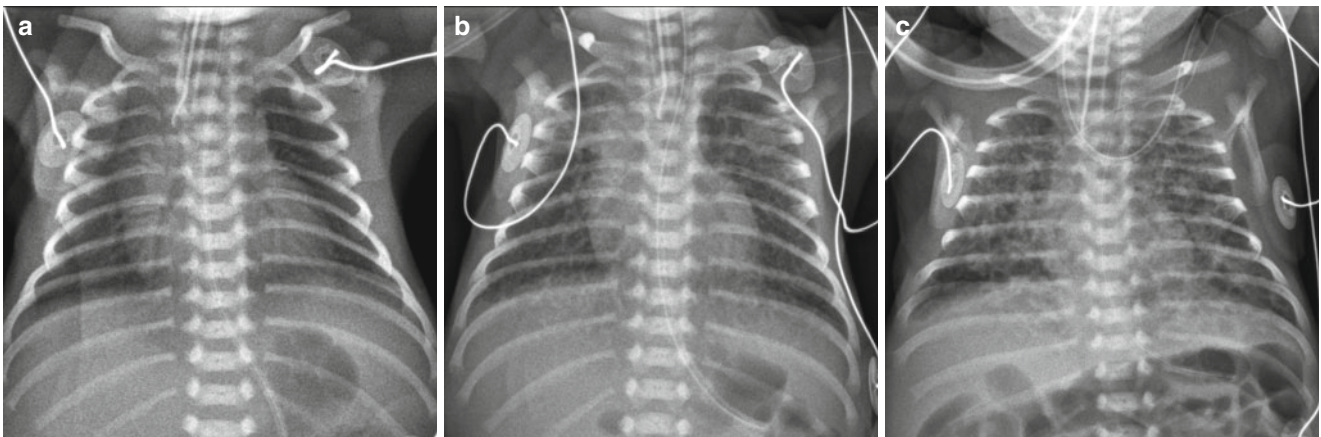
Ureaplasma urealyticum* pneumonia in a 26-week-gestational-age newborn. (a) On initial anteroposterior radiograph obtained on the day of birth, there is no evidence of pulmonary change. (b) Two days later, bilateral reticular opacities begin to appear. (c)
